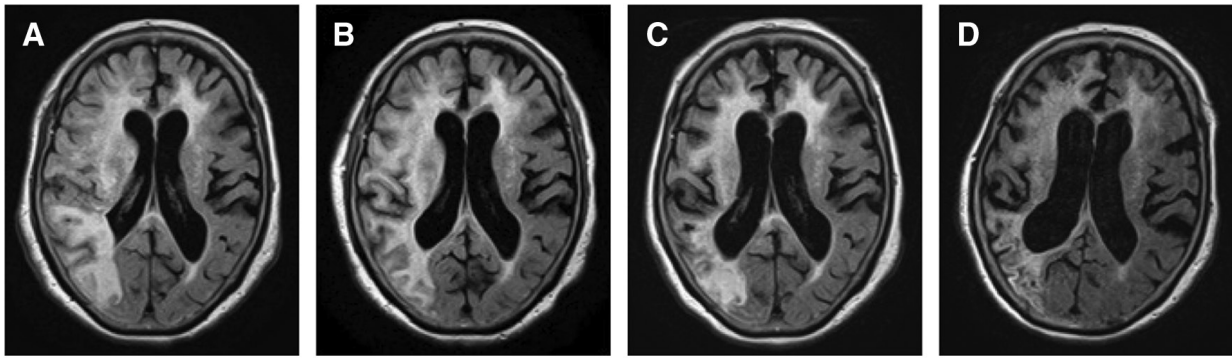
Changes in MRI findings over time. Hyperintense lesions in the right subcortical white matter on FLAIR gradually disappeared. (A) Day 12 (the day after second PTA), (B) day 16, (C) day 25, and (D) day 43. PTA: percutaneous transluminal angioplasty
